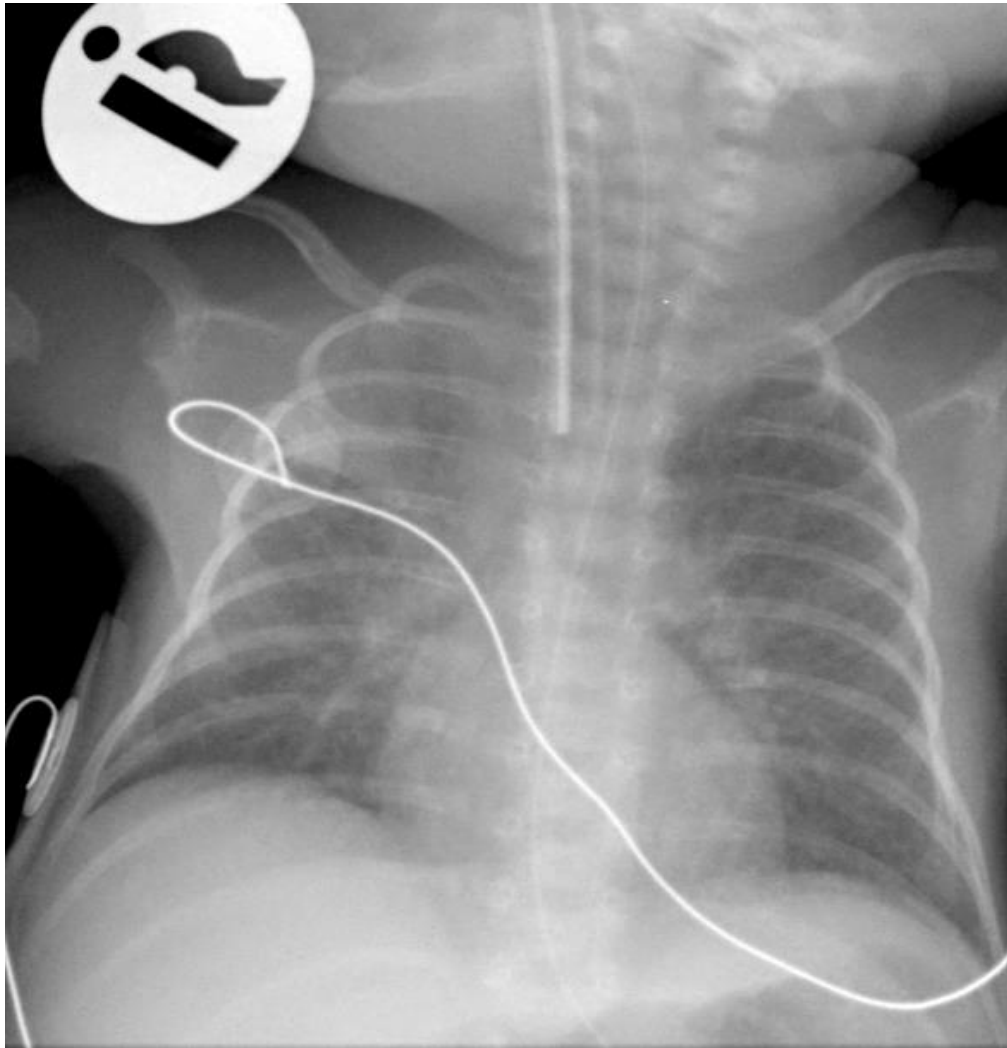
b: Low-dose 1,6 mAs X-ray after repositioning of endotracheal tube. Improvement of the right upper lobe consolidation is clearly visible on this low-dose image.
